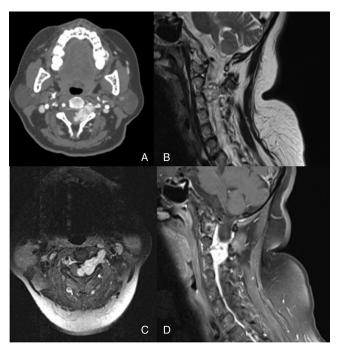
(A) Contrast-enhanced CT demonstrating a lesion in the left neural foramen at the C2–C3 level; (B) the tumor has a heterogeneous signal in T2 and (C–D) avidly enhances following Gadolinium injection and is responsible for significant compression of the spinal cord.
